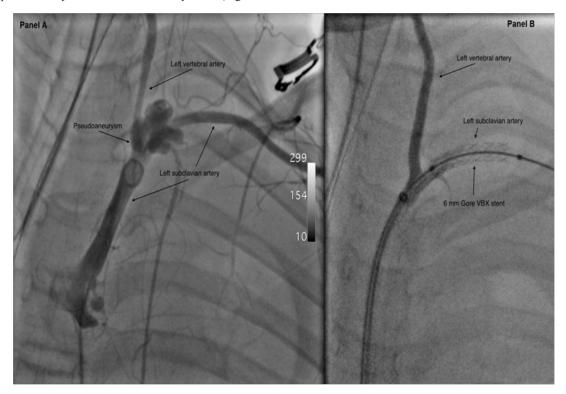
Figure IA & IBA chest X-ray showed a large left pleural effusion and a subsequent CT chest demonstrated a large left hemothorax with a psuedoaneurysm of the left subclavian artery (LSCA) at the base of the vertebral artery.
